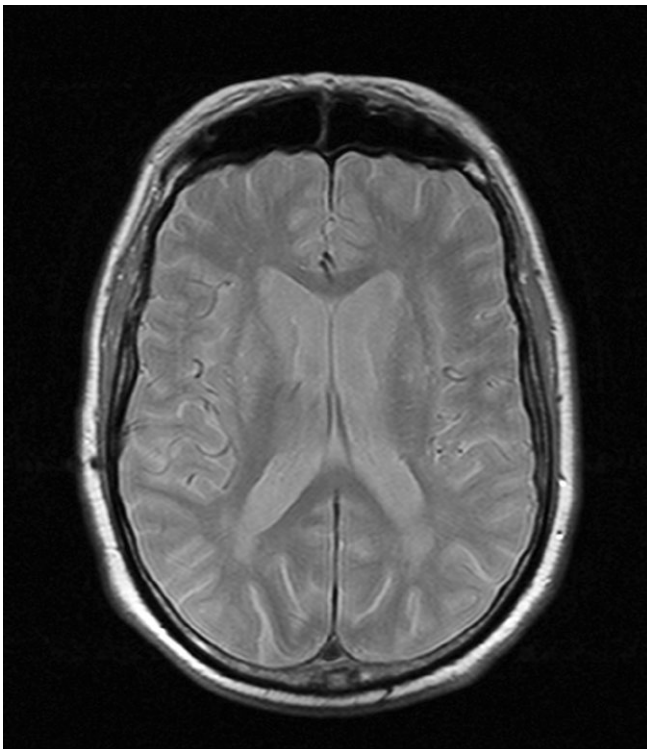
Brain magnetic resonance showing changes of the cerebral white matter signal with changes of several small foci of hyperintensity in FLAIR, without diffusion restriction.
